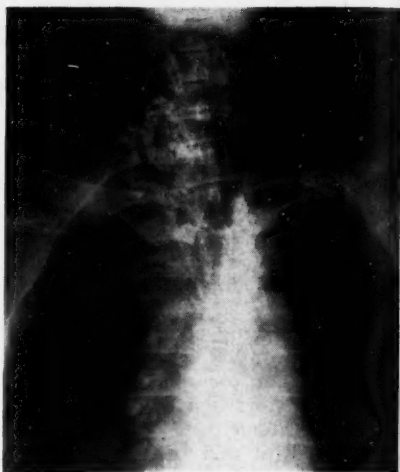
Roentgenogram showing diffuse calcification of the right lobe of the thyroid.
